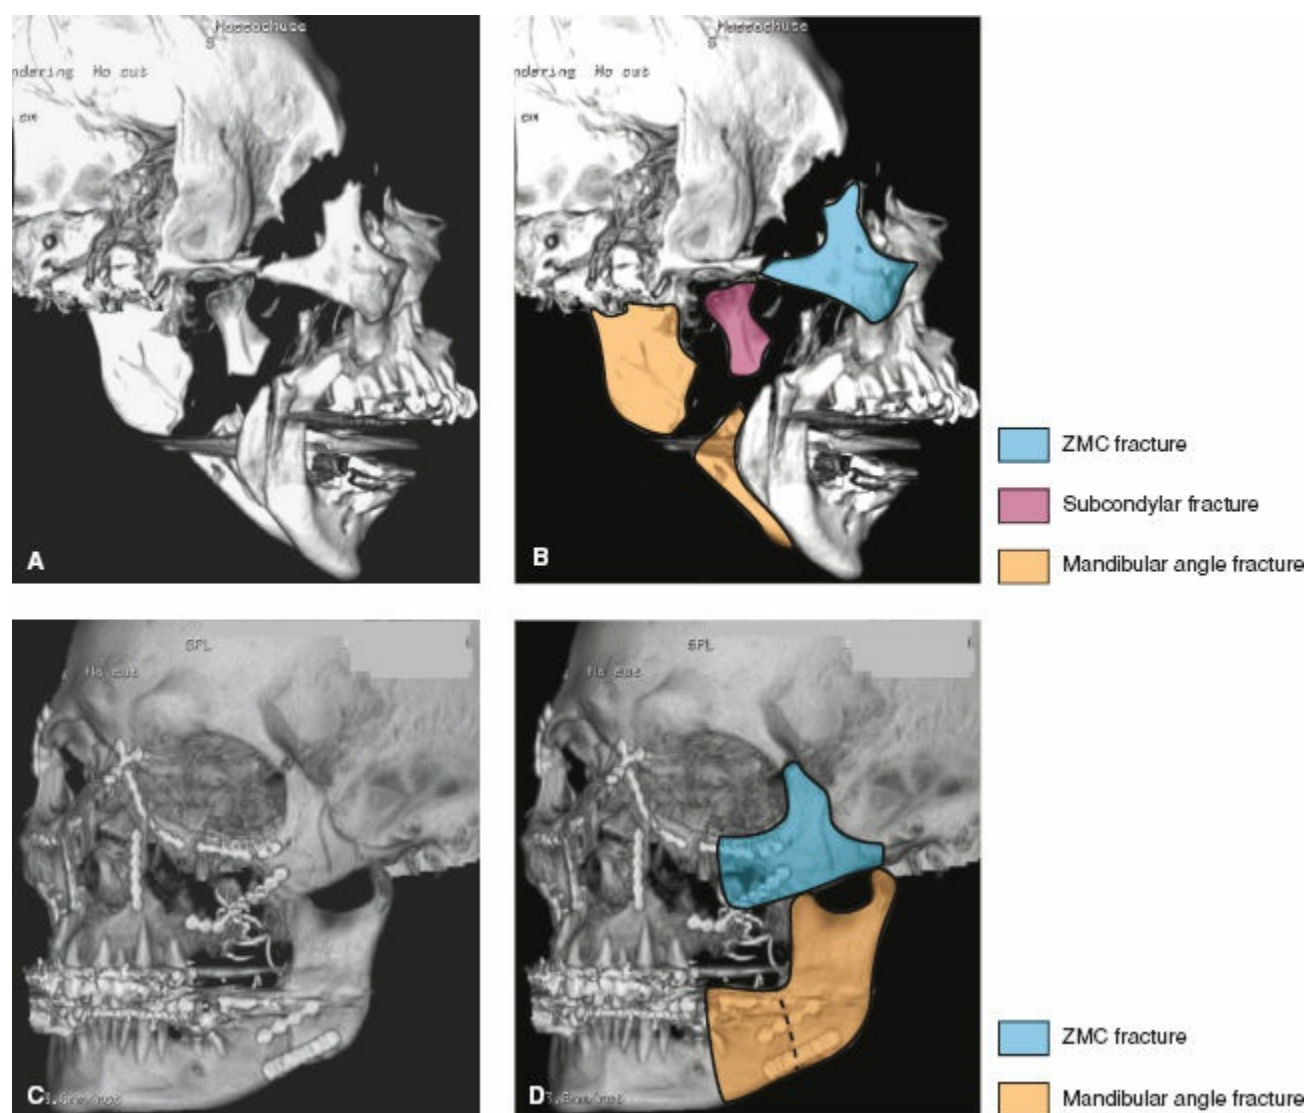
A: Lateral view of CT scan from same patient showing partial facial amputation. B: ZMC fracture and mandibular subcondylar and angle fractures highlighted. C,D: Postop CT scan showing reduction and fixation of ZMC and mandible fracture.
